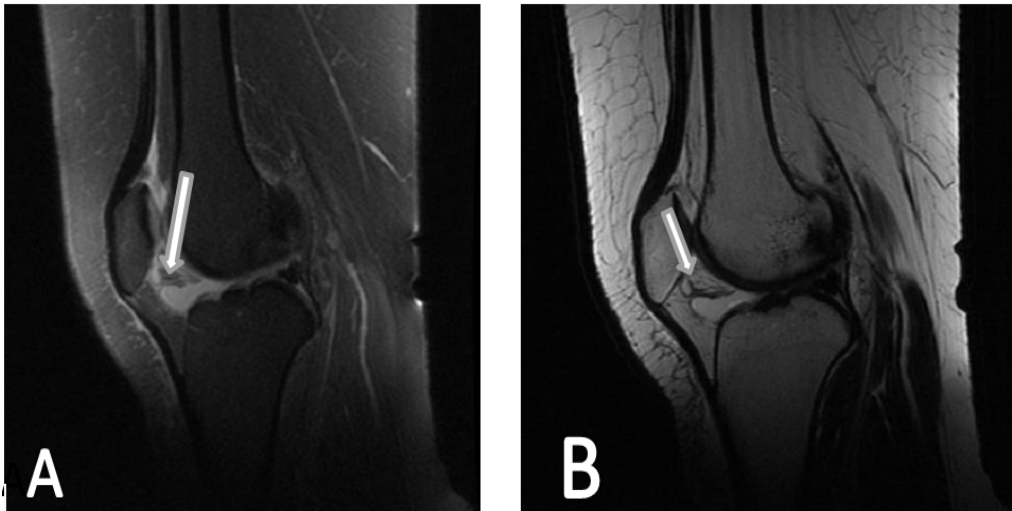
A. sagittal PD weighted image & B. sagittal T2-weighted image showing a well defined hyperintense cystic lesion within Hoffas pad of fat (arrow)
